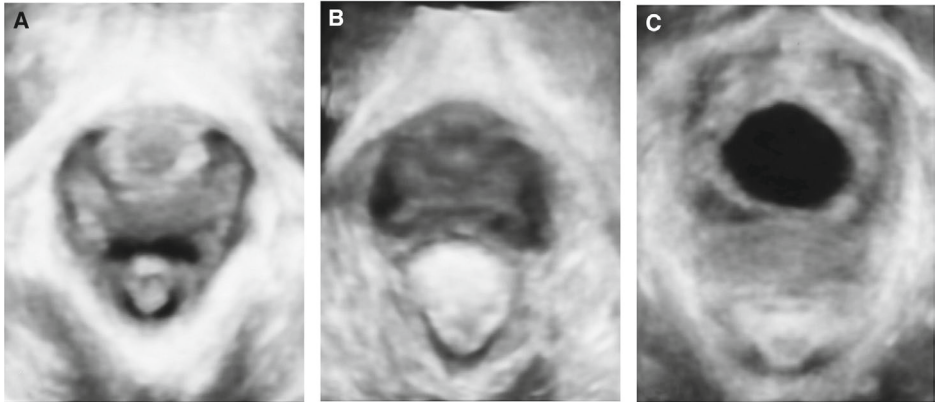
Normal hiatus, mild, and marked levator ballooning during maximal Valsalva. Example of a normal (A) hiatus during maximal Valsalva with 3D/4D transperineal ultrasound and mild (B) and marked (C) levator ballooning.
